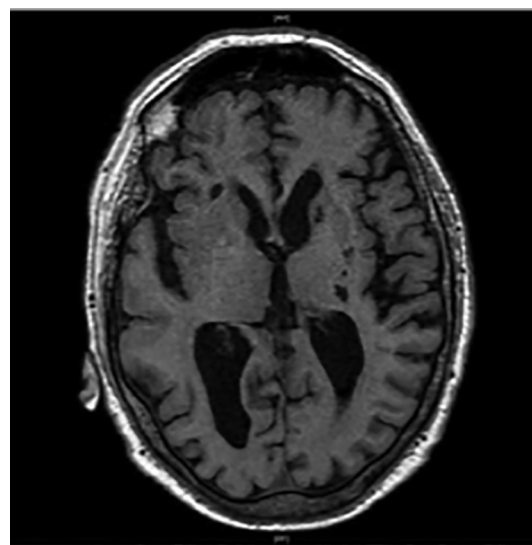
Magnetic Resonance imaging of the patient which failed to show an underlying ischemic or structural pathology which could have been contributing to his symptoms.
